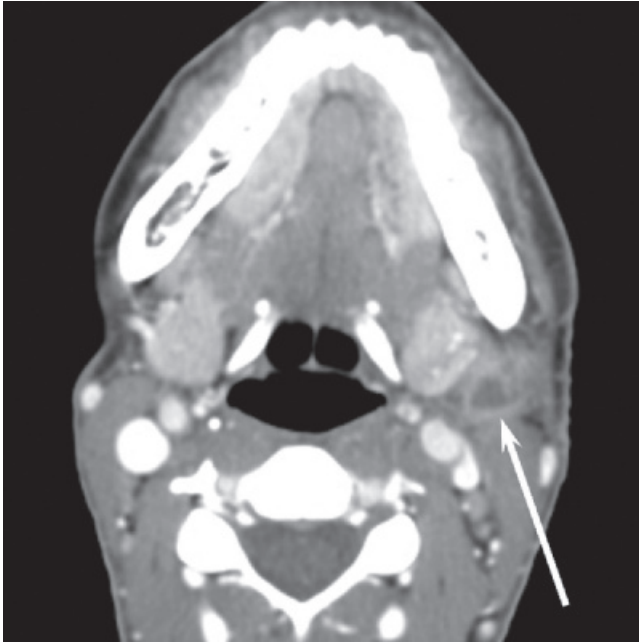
Tuberculous adenitis. Axial contrast-enhanced CT shows an abscessed lymph node (arrow) at the tail of the left parotid. TB-infected nodes may be of low density, or may become frankly abscessed.
